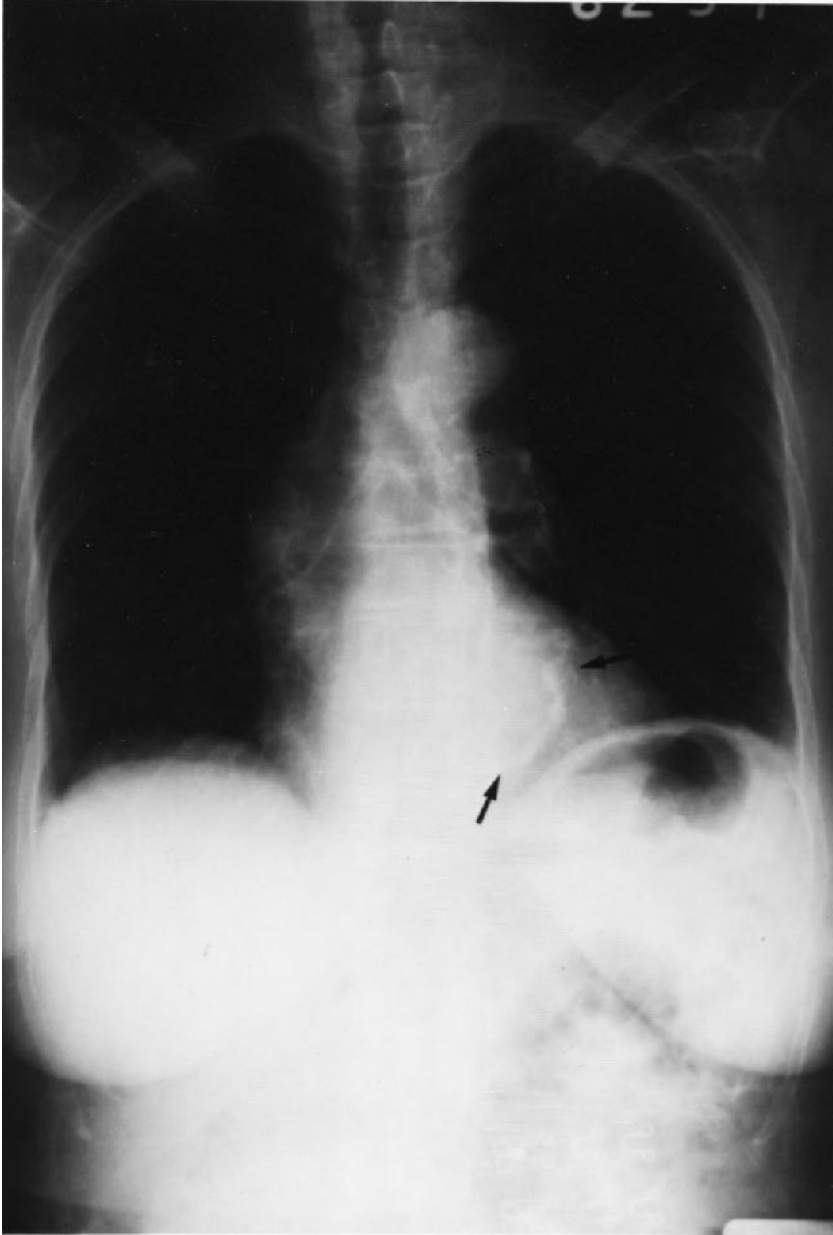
Posterior-anterior chest x-ray in a patient with J-shaped calcification of the mitral annulus (arrow).
